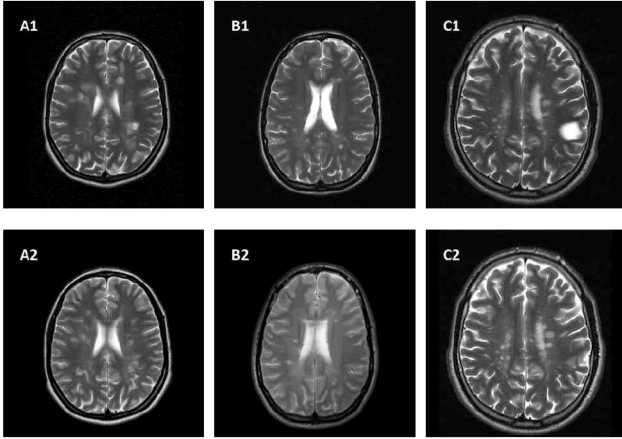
Sample MR images from the MS database of the eHealth lab. A1, B1 and C1 MR slices were obtained from the patient's first scan. A2, B2 and C2 show the MR image of the near point taken from the 6 or 12 month periodic examination of the same patients
